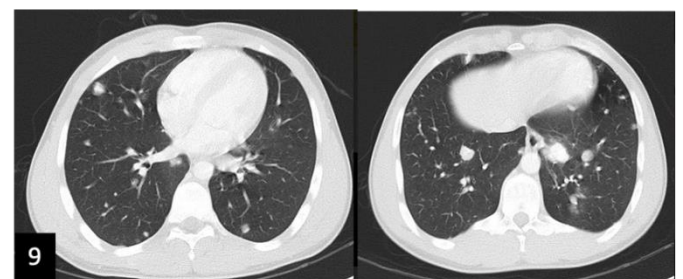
Thoracic-abdominal CT scan showed pulmonary metastasis.
